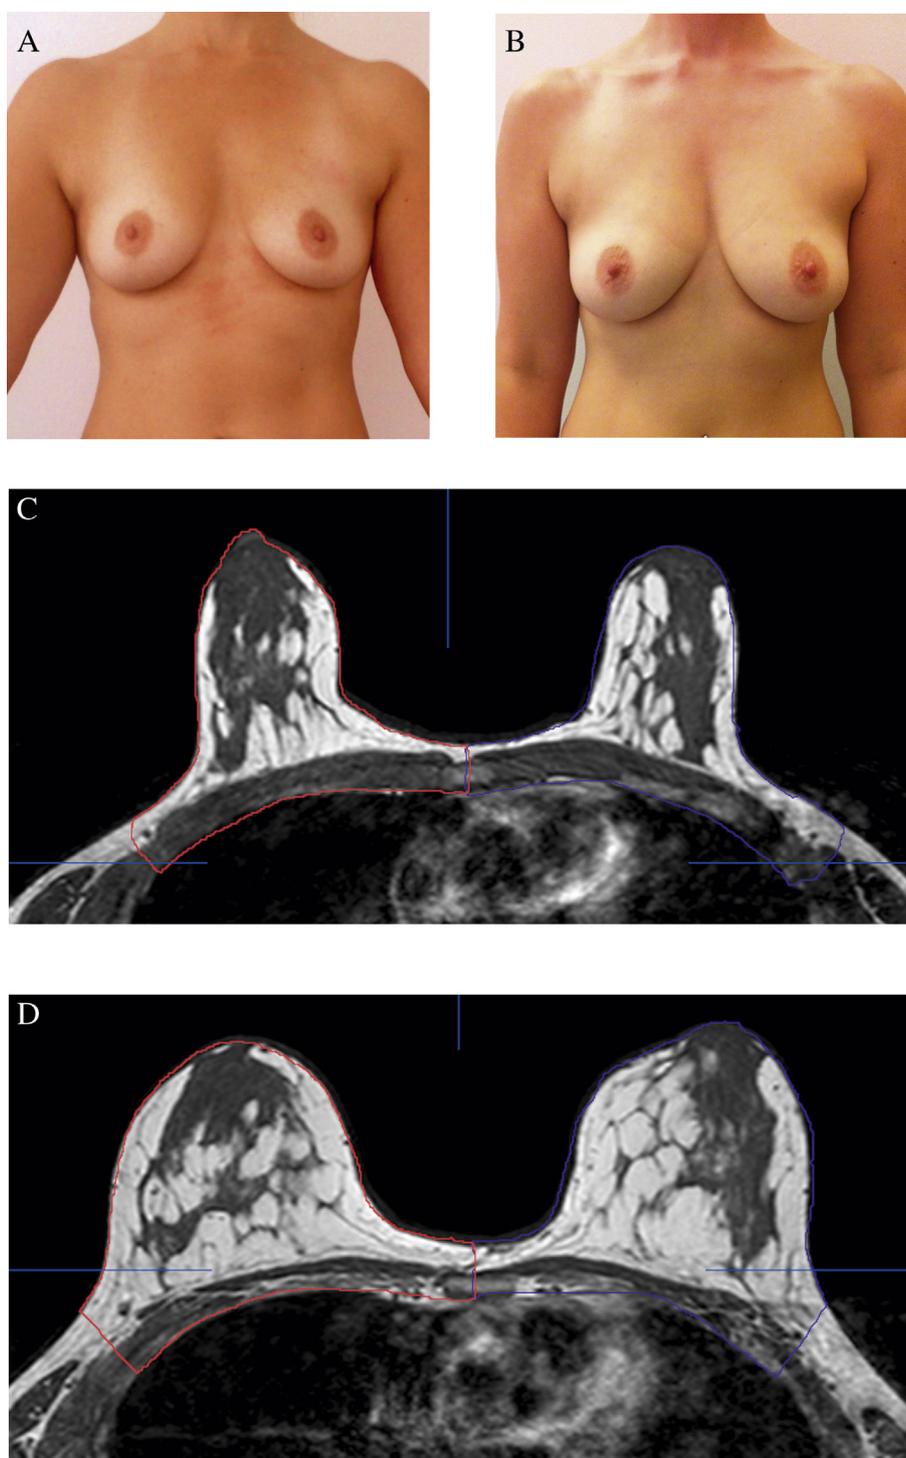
The patient number 16 in Table 1, treated with WAL only without stem cell enrichment, before (A) and 1.5 years postoperatively (B), with MRI pictures before (C) and after 6 months (D). Notice the absolutely natural appearance of the breasts and increase in adipose tissue layer (white) surrounding the breast glandular tissue (black) and red and blue markings of the volumetric analysis.
